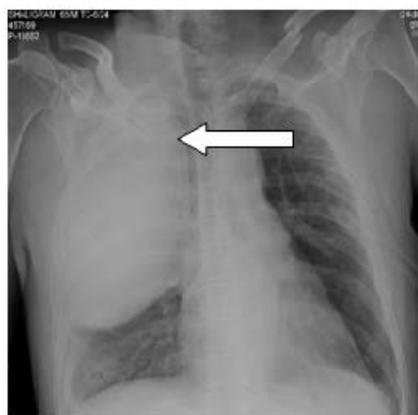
Chest x-ray done 4 days after injury showing large radio-opaque shadow in upper 2/3rd of the right hemi-thorax but right costophrenic angle is free.
